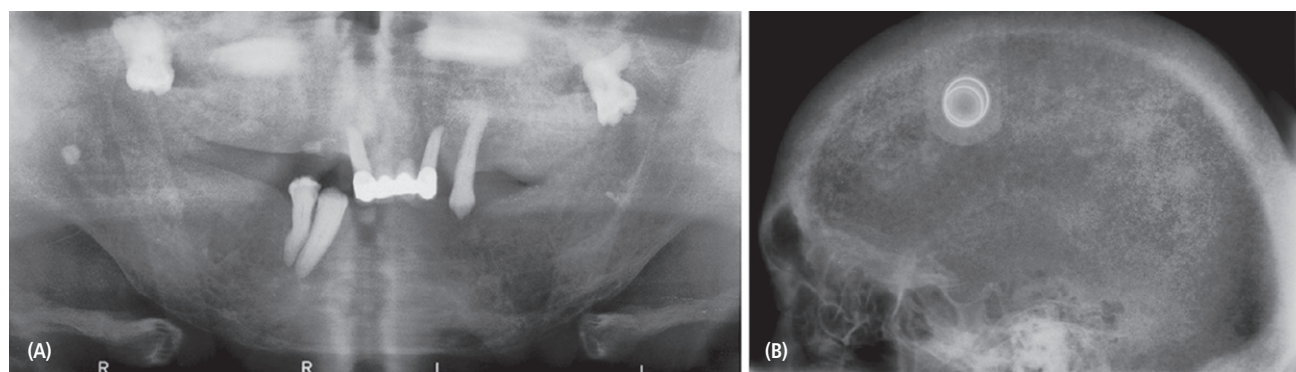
Radiographs at presentation. A. Panoramic radiograph. B. Lateral skull radiograph demonstrating the "ground glass" appearance of the trabeculae.
